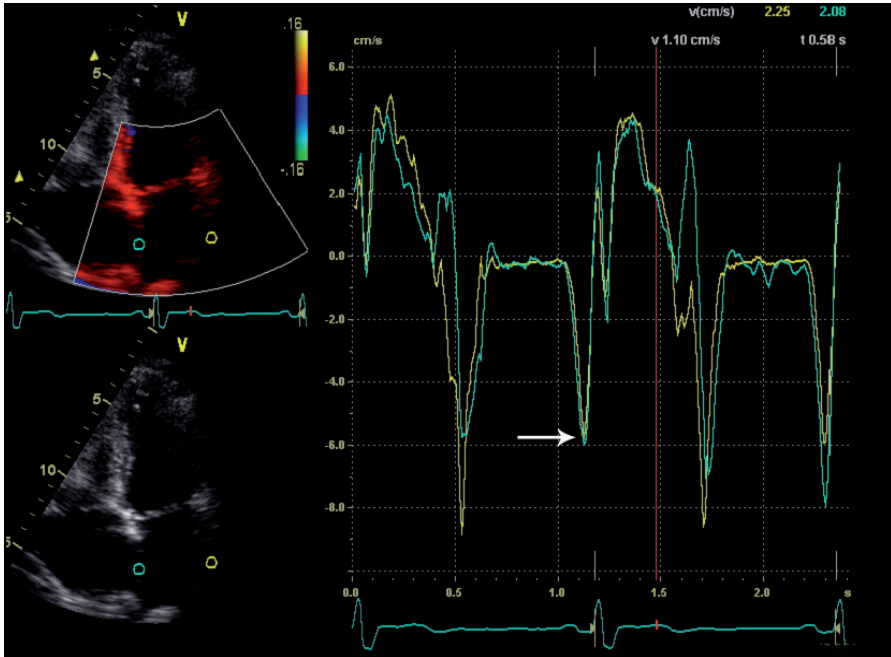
Tissue velocity echocardiography (TVE).
